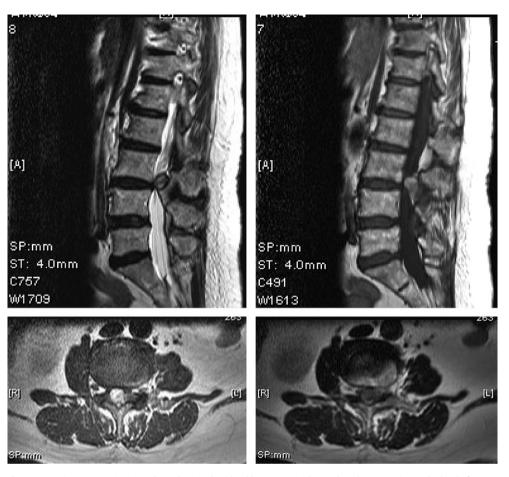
Magnetic resonance imaging showed a spinal epidural hematoma with spinal cord compression at the level of L3-L4.
